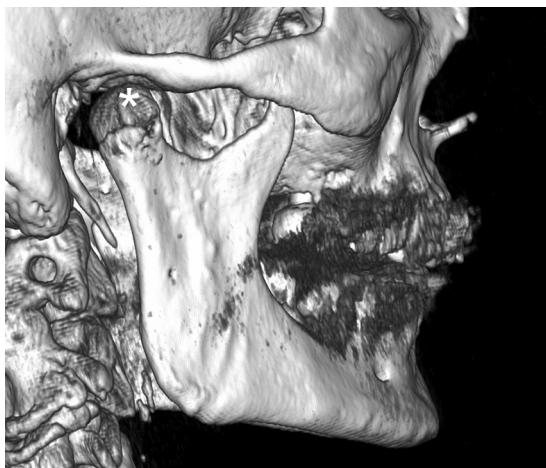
Postoperative computed tomogram showing restoration of the height of the mandibular ramus and the head of the mandible reduced to the glenoid fossa (*). The screw heads are invisible as they are embedded in the bone. The open bite on the left side was eliminated. Digital occlusal analysis by interdental pressure mapping confirmed that the sides were balanced.
